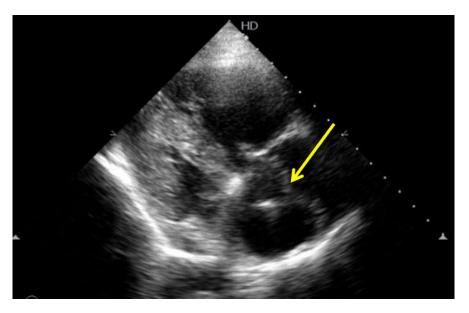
Transthoracic echocardiography showing thrombus in right atrium
